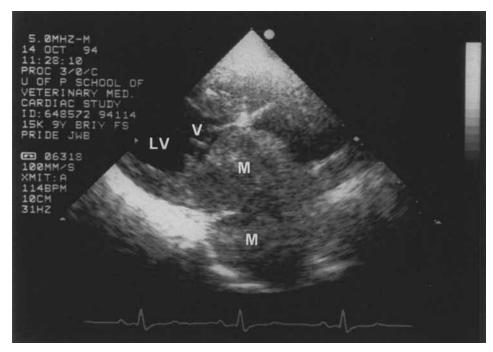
Two-dimensional echocardiogram. Right parasternal, long axis view. A 4.5×6.5 -cm, homogeneous mass (M) appears to fill the left atrium and extend into caudal pulmonary veins. LV, left ventricle; V, mitral valve.
